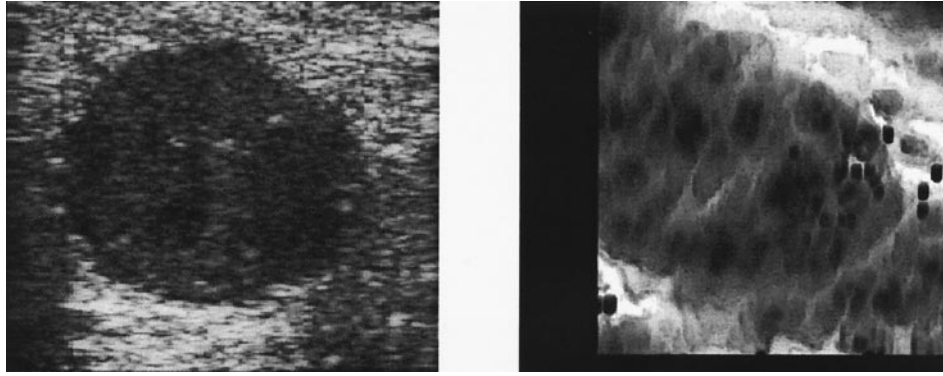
(Left) Sonogram and (Right) elastogram of a multifocal invasive ductal carcinoma *in vivo*, obtained at 5 MHz. Observe the multiple low strain foci (lack) within the elastographic tumor, some of which correspond to the positions of micro-calcifications in the sonogram. Image width is 40 mm. In the elastogram, black = hard; white = soft.
